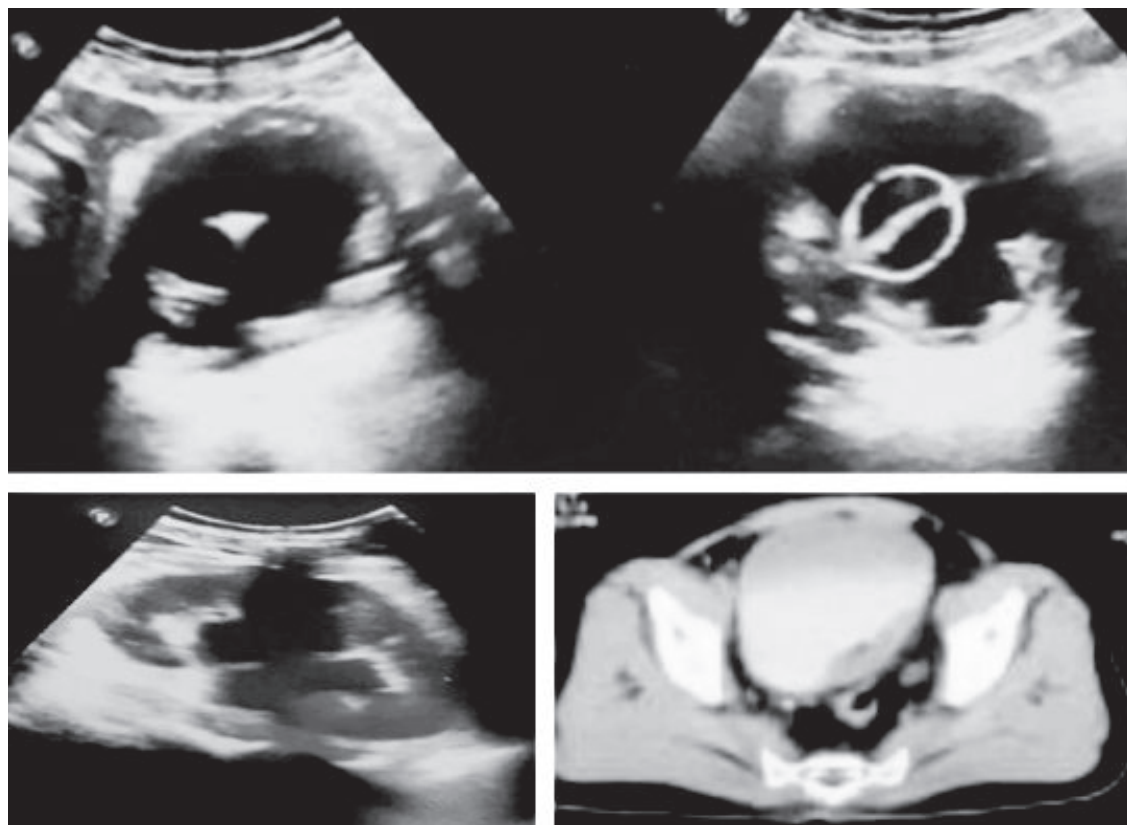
4b (Top images) & 4c (Bottom left image): *showing USG & 4d (Bottom right image): CT Urogram axial image showing Urinary bladder mass with left VUJ invasion resulting upstream urinary obstruction.*
